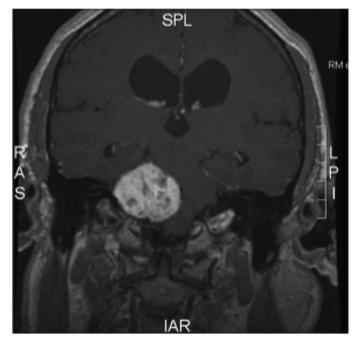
MRI coronal scan T1-weighted after Gadolinium enhancement showing a giant vestibular schwannoma of the right cerebello-pontine angle.
